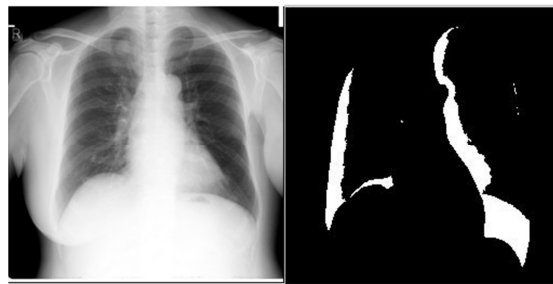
showing x-ray of patient and detected benign tumour
